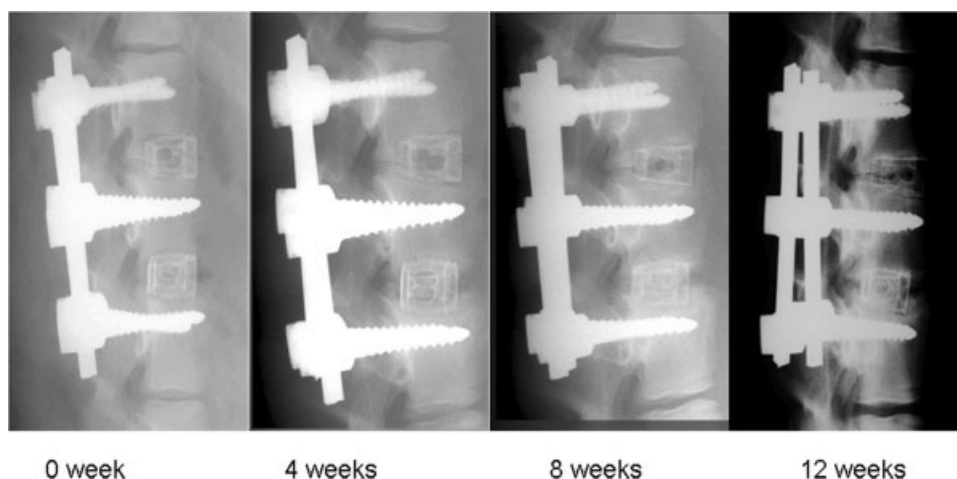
Serial X-ray examinations from immediate postoperation to 12 weeks after. Images show that the lower level (L4/5) has a slightly higher density.
